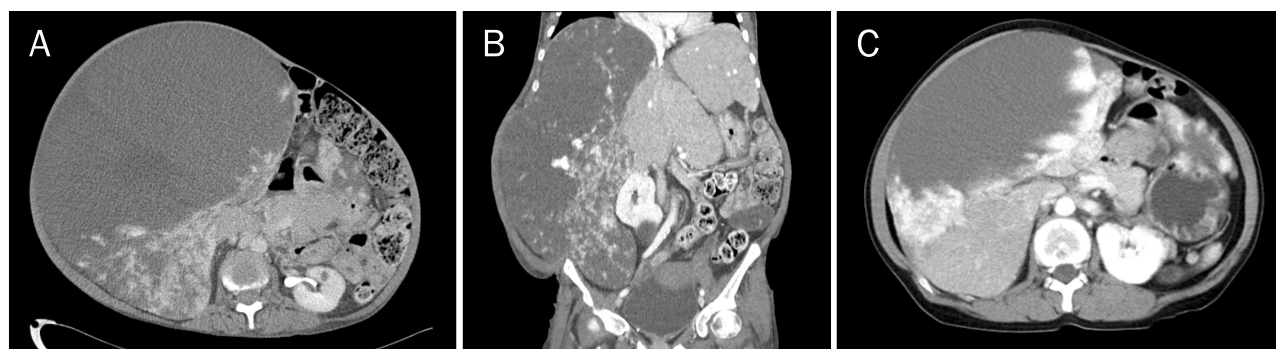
Abdominal CT scan at presentation with several centripetal enhancing exophytic masses in both hepatic lobes (maximum size, 32.3×27.5×25.4 cm). (A) Cross section image. (B) Coronal section image. (C) Cross section image of abdominal CT 8 years prior (maximal size, 22.3 cm).
